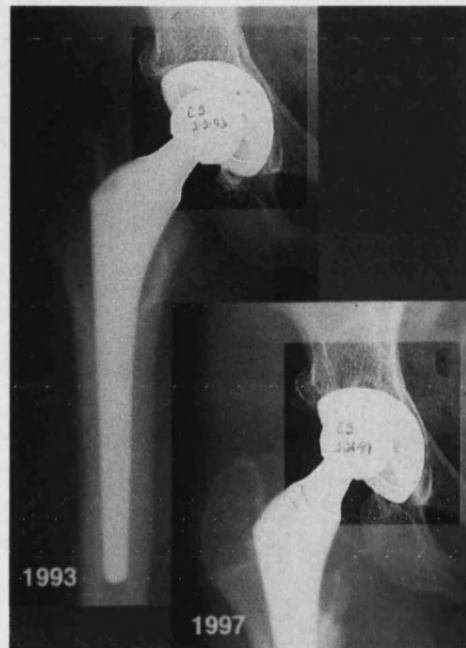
Clinical x-rays post –op and after four years showing development of osteolytic void [29].
